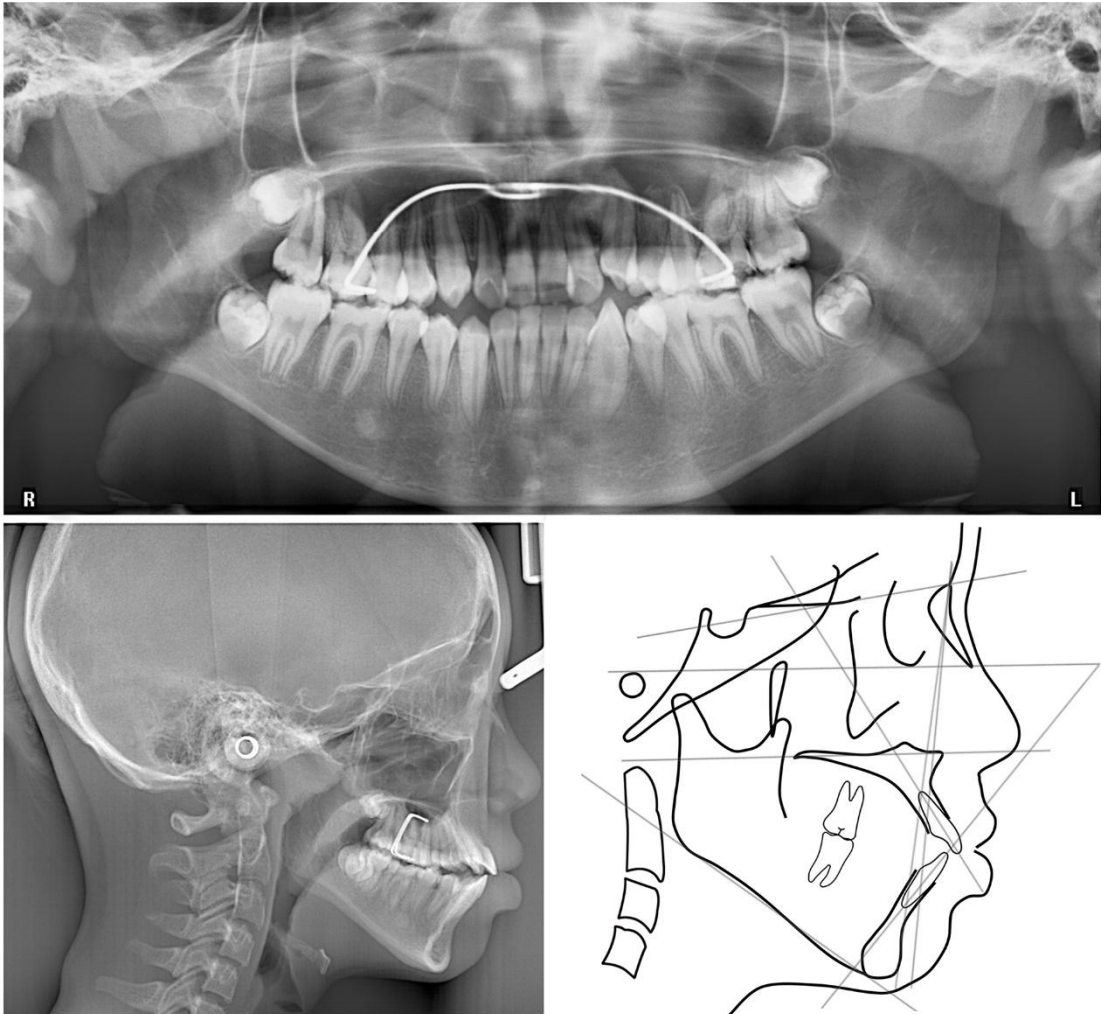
Posttreatment panoramic and lateral cephalometric radiographs and tracing after mSLBB treatment.
